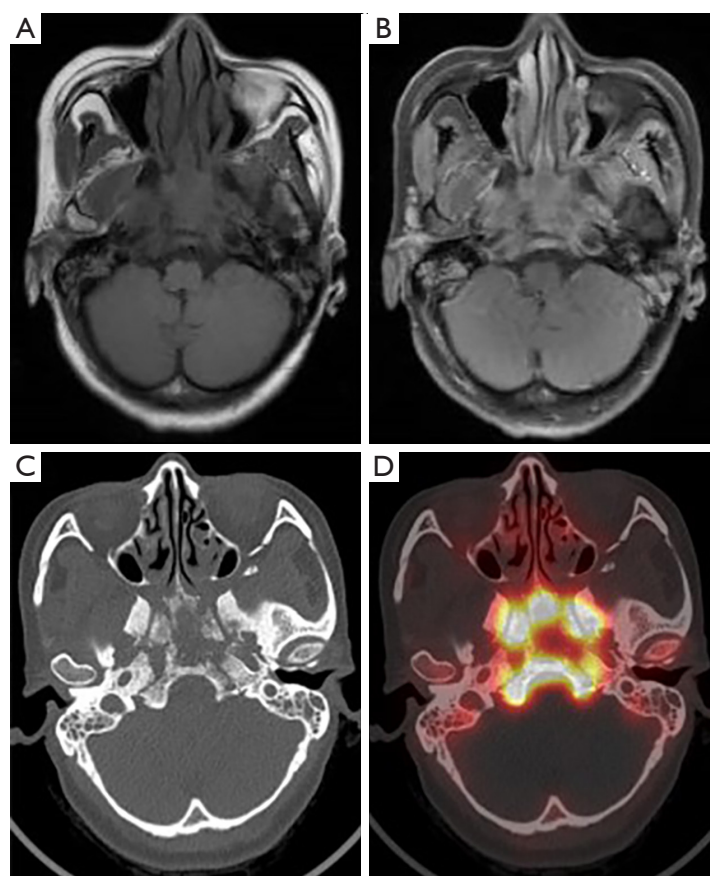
Images of a 45-year-old female patient diagnosed with NPC. (A) MRI-T1WI and (B) its contrast-enhanced variant demonstrated widespread SBBI, encompassing the clivus, sphenoid wing, and pterygoid process. (C) CT imaging revealed numerous osteolytic and osteogenic alterations in the skull-base bone. (D) The ^{18}F -NaF PET/CT image showed marked abnormal accumulation of ^{18}F -NaF in the lesions. The MRI observations were in agreement with the ^{18}F -NaF PET/CT findings in the detection of SBBI. NPC, nasopharyngeal carcinoma; MRI, magnetic resonance imaging; T1WI, T1-weighted imaging; CT, computed tomography; ^{18}F -NaF PET/CT, ^{18}F -sodium fluoride positron emission tomography-computed tomography; SBBI, skull-base bone invasion.
